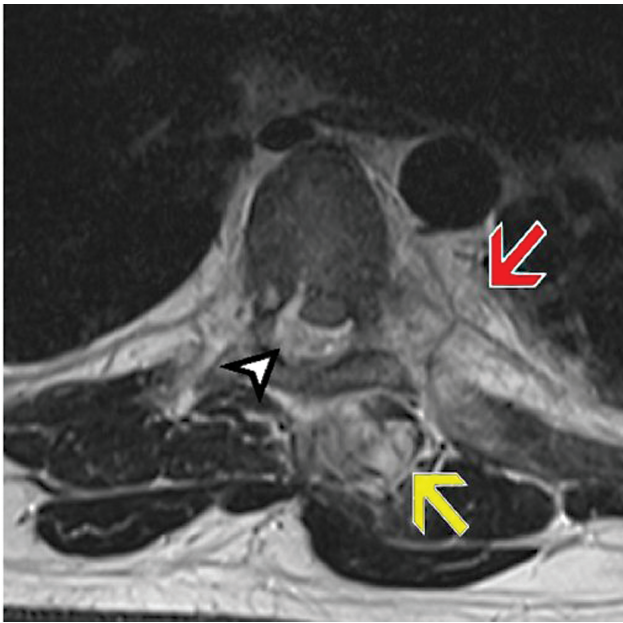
A thoracic spine T2-weighted axial MRI showing a fluid collection with hypersignal in the epidural space (arrowhead), displacing the spinal cord anteriorly, and also other discrete fluid collections with hypersignal on the intrathoracic paravertebral (red arrow) and extra-thoracic paraspinous (yellow arrow) areas. MRI, magnetic resonance imaging.
